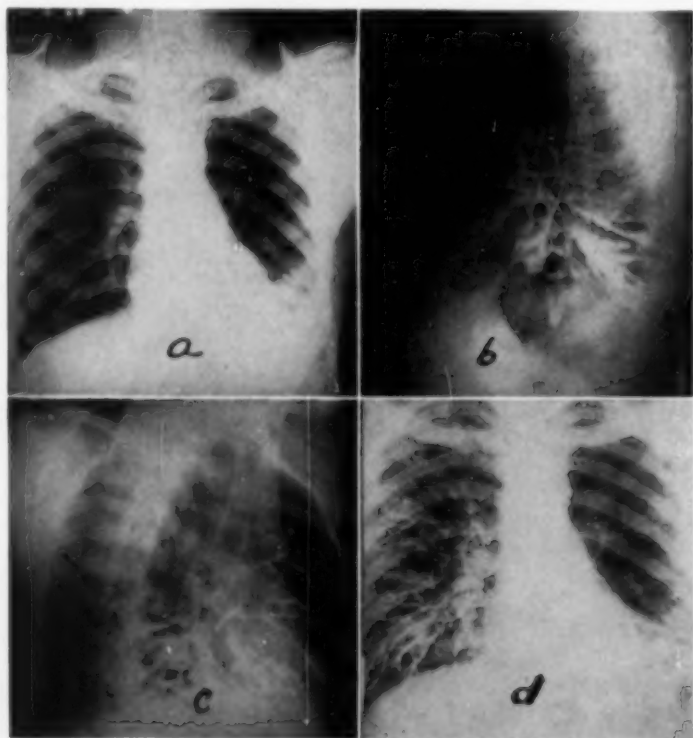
represents a 20 year old colored male with sputum positive for tubercle bacilli. Roentgenogram (a) showed moderately heavy density overlying the left hemidiaphragm. He expectorated a large amount of sputum especially in the early morning hours. Bronchography of the left side with Ioduran B, (b and c) demonstrated advanced bronchiectasis of the lower lobe. Six minutes later a bronchogram of the right lung was performed with the same medium (d). The left lung shows only increased bronchial markings and no residual of Ioduran B. Thus he had coughed up most of this medium within six minutes.
